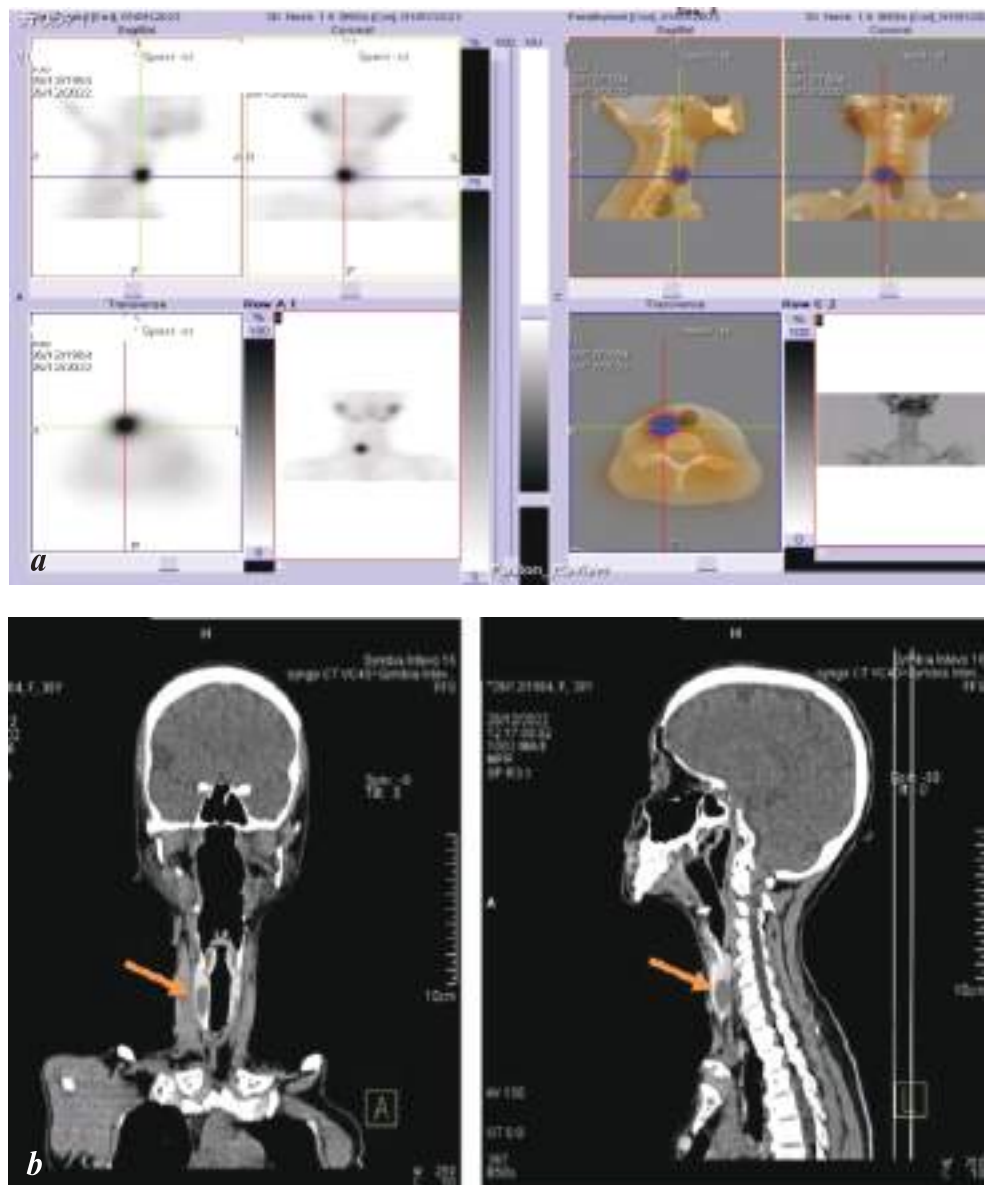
a) Delayed (120 minutes) images of ^{99m}Tc-sestamibi parathyroid scintigraphy in the same patient showed persistence of tracer uptake in the right lower pole area of the thyroid gland. b) Corresponding CT images of parathyroid adenoma (arrow) in coronal and sagittal planes demonstrating the precise location of an ovoid mass in the lower right parathyroid region.
